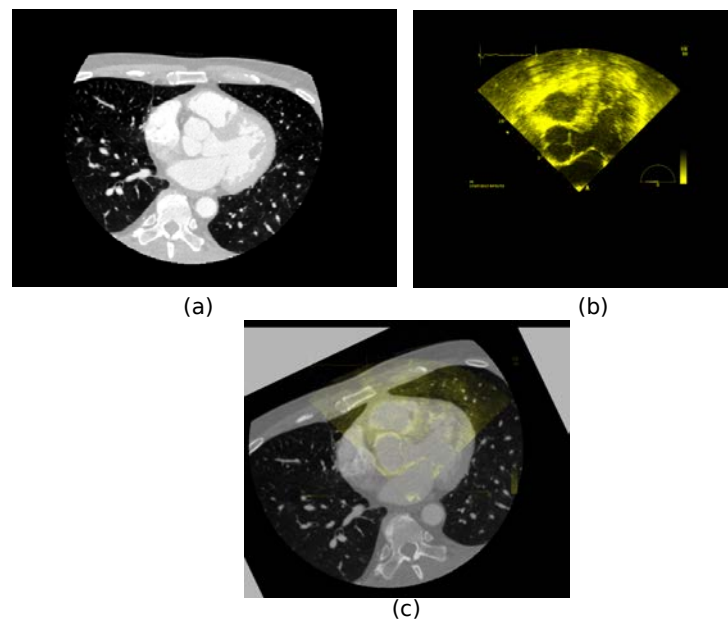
a) US Image 2. b) Resampled CT image. c) Result of the our proposed registration.
